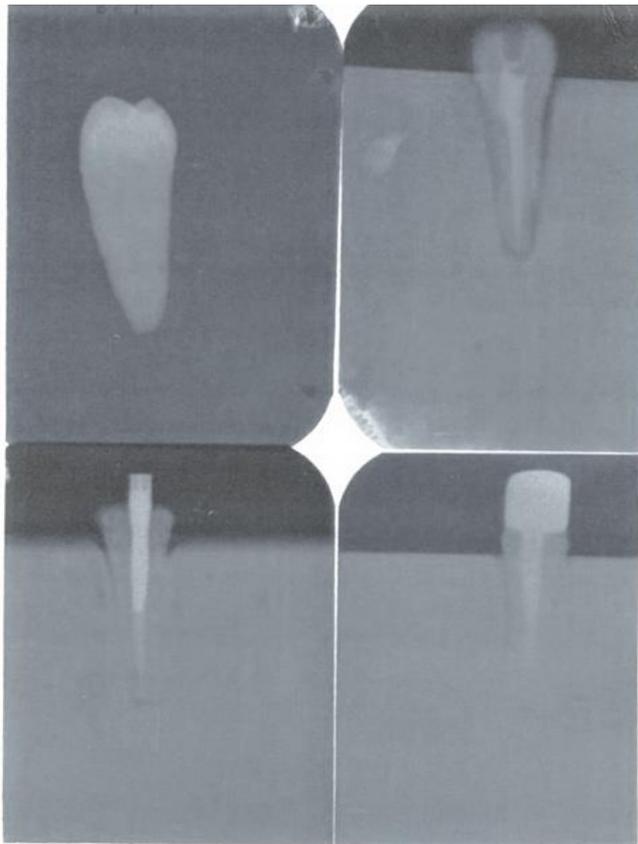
Radiography evaluation of the tooth, randomized controlled trial , proper dowel, and sample
